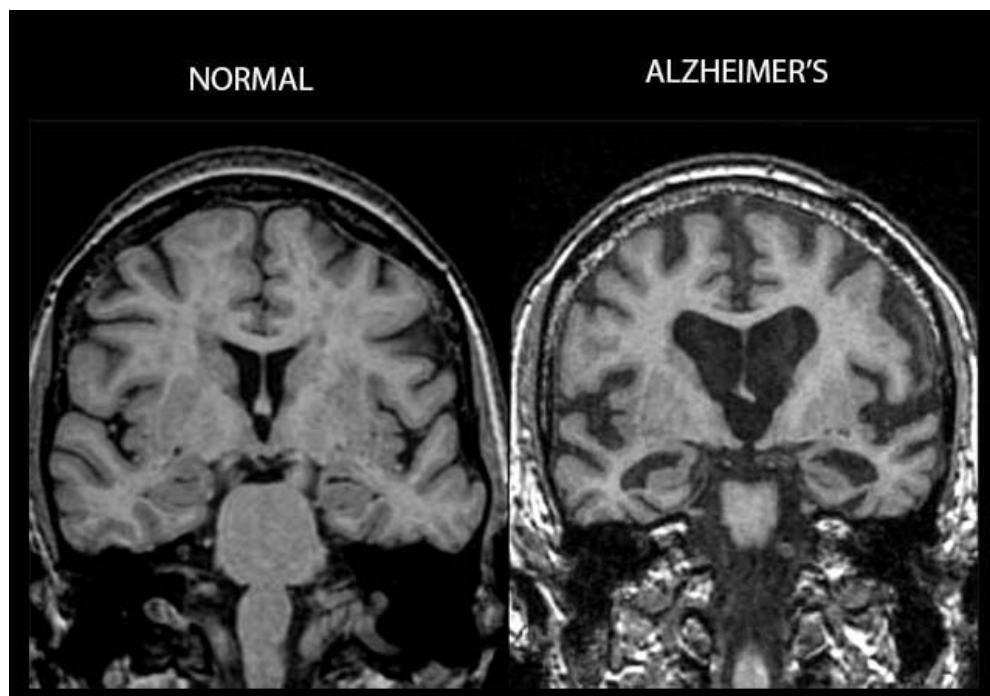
MRI imaging of human brains. Image of the human brain (left) healthy and (right) affected by Alzheimer's Disease, dark spaces in the AD image represent the accelerated neurodegeneration - Adapted from John Hopkins University [59].
